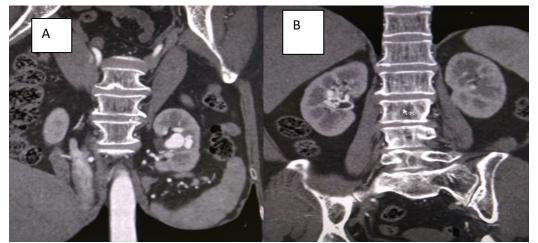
(Renal CT angiography): coronal CT angiography reconstruction A & B images of patient show increased vascularity with multiple irregular dilated tortuous vessels of different sizes which include both arterial and venous circulation filling simultaneously in the region of left and right kidneys respectively
